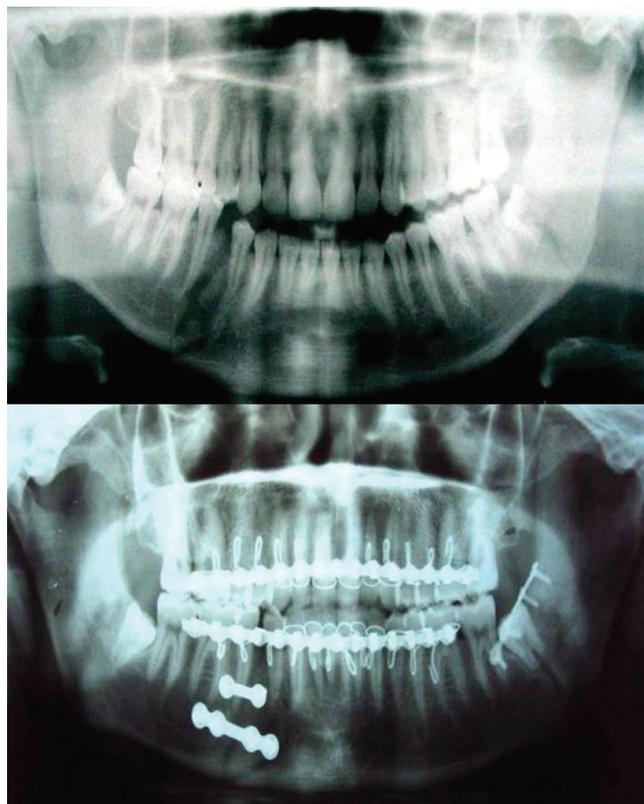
Pre and Postoperative Orthopantomogram revealing fracture left angle & right mandibular body fixed using miniplates
